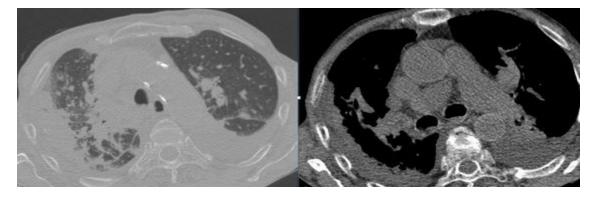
AXIAL HRCT thorax lung and soft tissue window (left image, right image) showing bilateral pleural effusions in the dependent regions with underlying consolidation.
